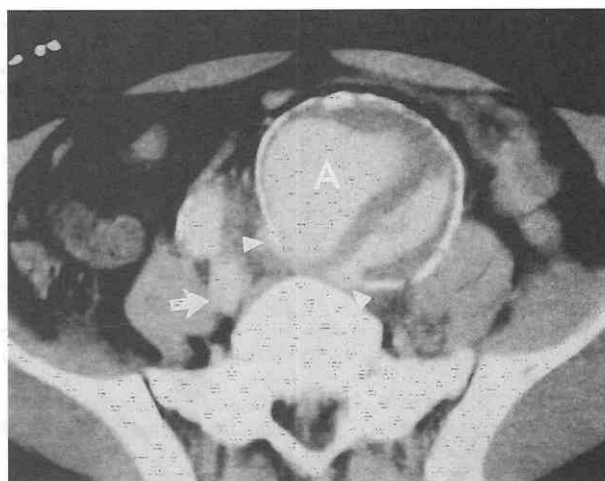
Arteriovenous fistula from ruptured iliac aneurysm. CT shows a large left iliac artery aneurysm (A) with complex internal channels. There was rupture (arrowheads) into the iliac vein with early venous contrast opacification (arrow) on this arterial-phase study.
